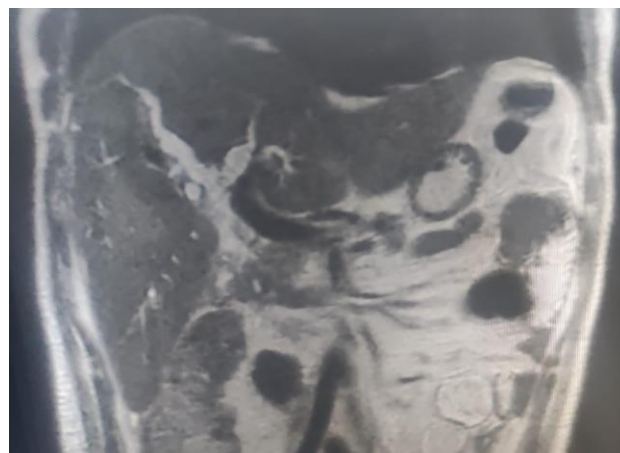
Frontal MRI section showing dilatation of the MBD, and IHBD, without individualization of the gallbladder.
